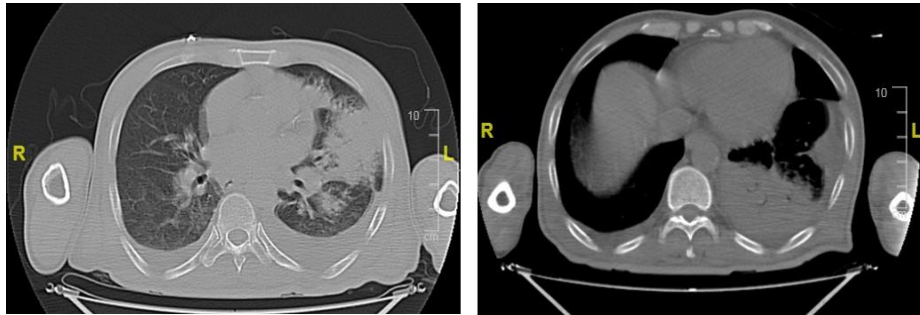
Chest CT. Subpleural confluent area of consolidation of lingula and left posterobasal segment with minimal underlying pleural effusion
